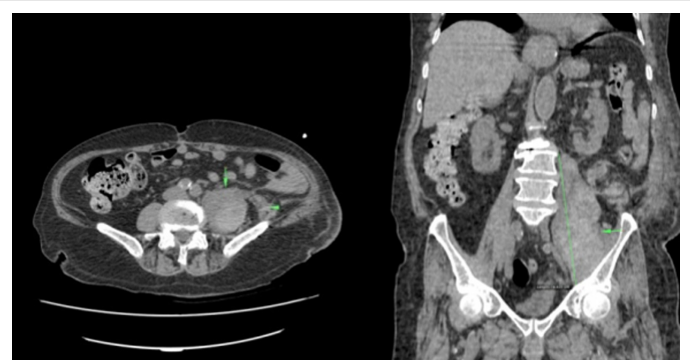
CT image of Case 1.
